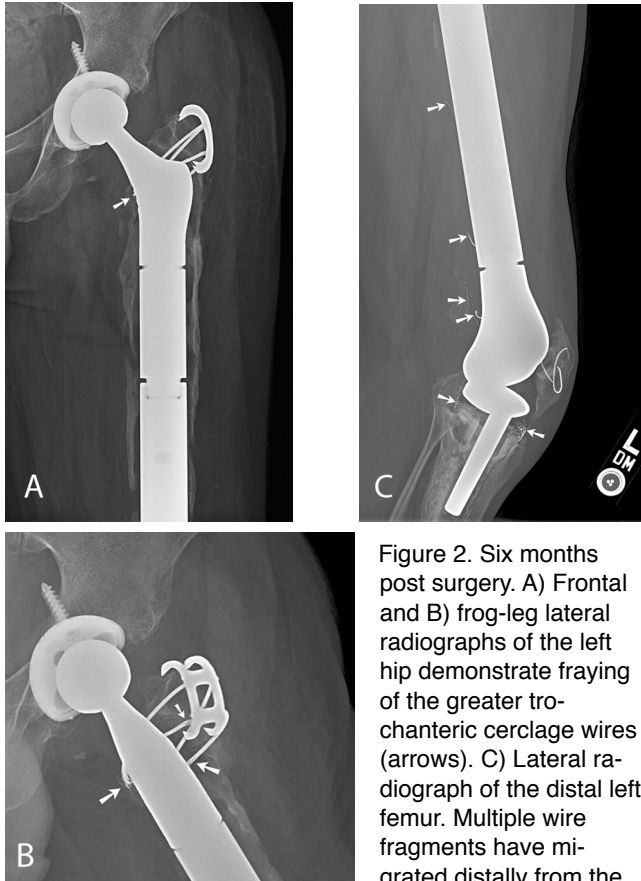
Six months post surgery. A) Frontal and B) frog-leg lateral radiographs of the left hip demonstrate fraying of the greater trochanteric cerclage wires (arrows). C) Lateral radiograph of the distal left femur. Multiple wire fragments have migrated distally from the hip joint (arrows); some are now located within the knee joint space.
